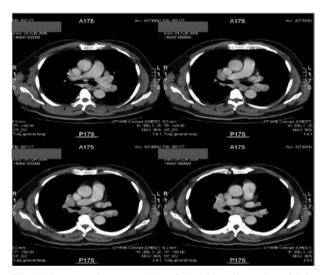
Computed tomography of the chest showed multiple enlarged mediastinal and bilateral pulmonary hilar lymph node
